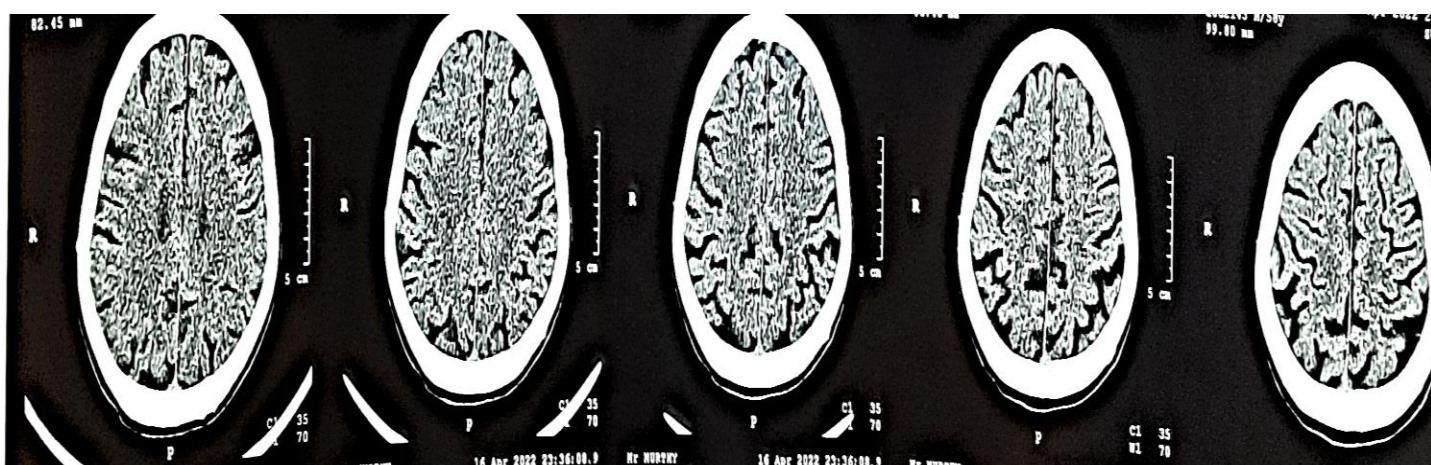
Brain CT scan shows prominent sulci and gyri indicating brain atrophy
